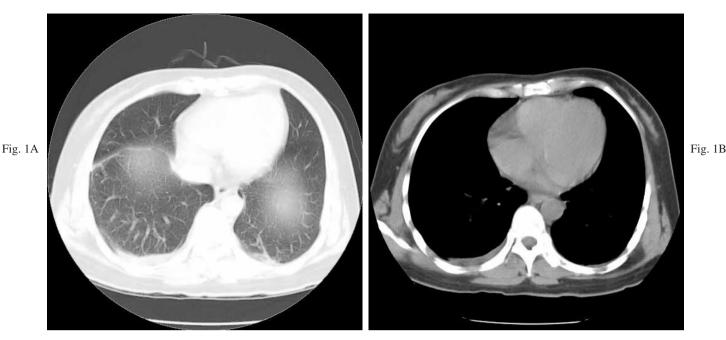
Pulmonary CT showing "bilateral pleurisy with right pleural effusion".
